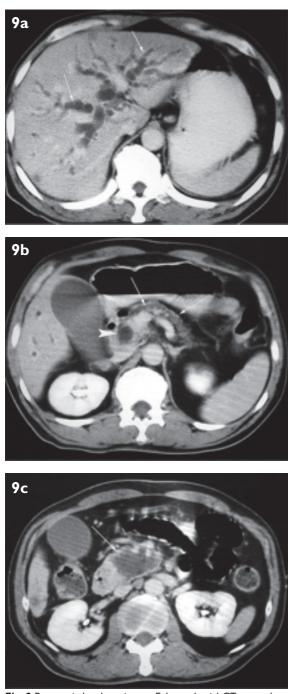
Pancreatic head carcinoma. Enhanced axial CT scans show (a) intrahepatic bile duct dilatation (arrows), (b) dilatation of the common bile duct (arrowhead) and an atrophic pancreas with dilated pancreatic duct (arrows) producing the "double-duct sign", and (c) a low-density mass (arrow) at the head of pancreas.
